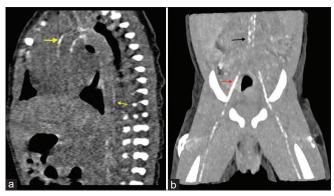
(a) Sagittal long axis computed tomography (CT) showing calcification involving ascending aorta and descending thoracic aorta (arrows) (b) Coronal CT image showing calcification in the abdominal aorta (black arrow), common iliac (red arrow) and its branches bilaterally
